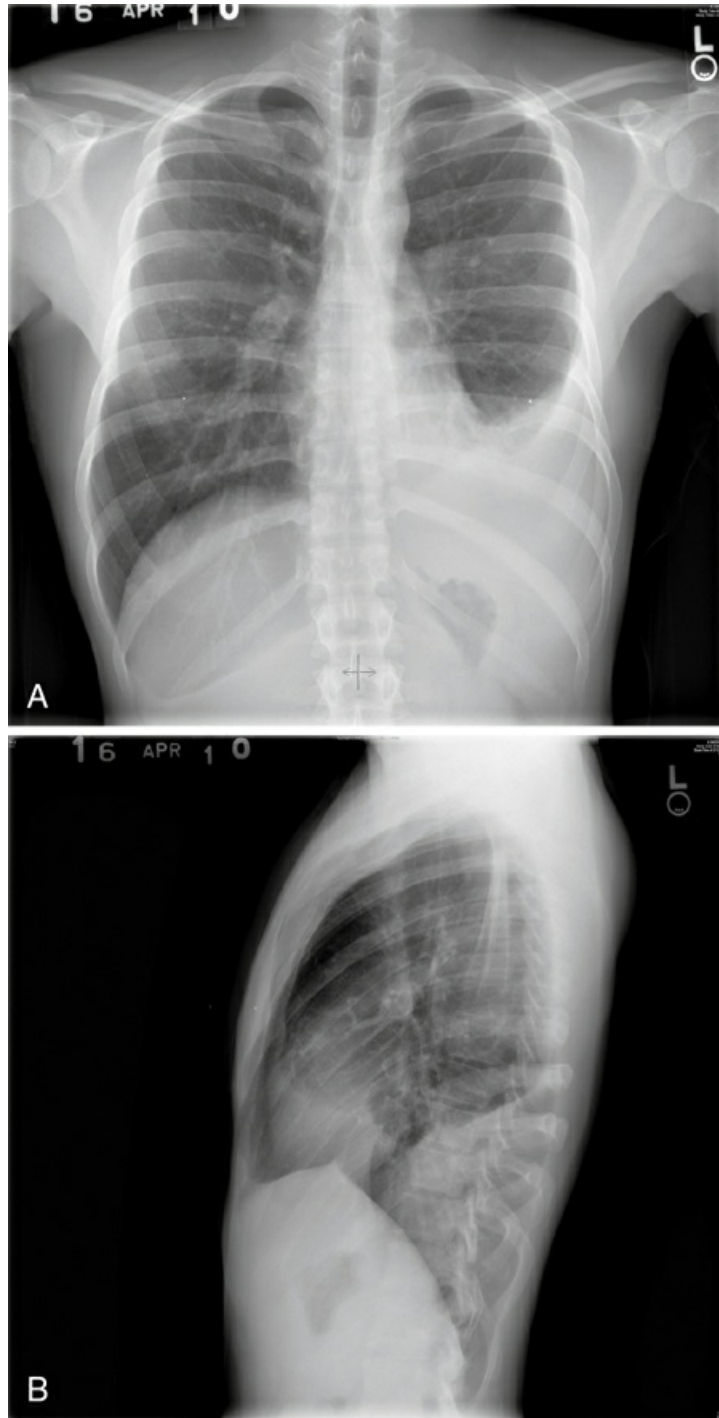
Posteroanterior (A) and lateral (B) chest radiographs demonstrating left pleural effusion.
